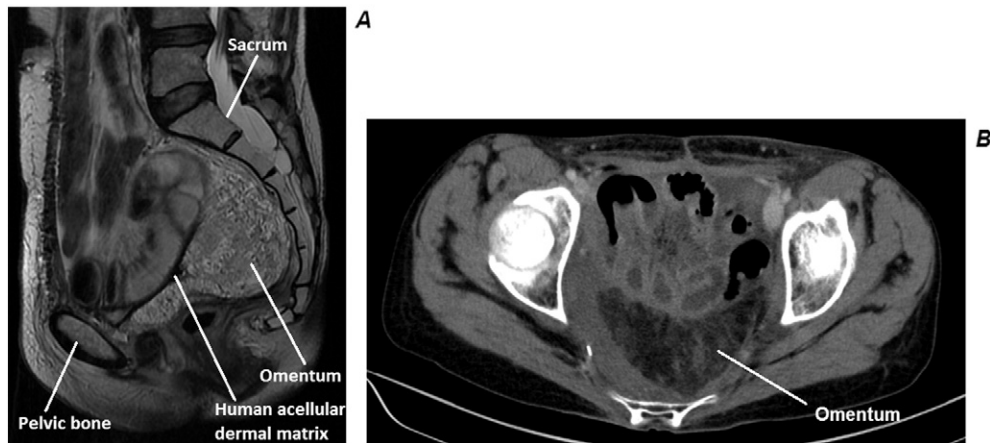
Final imaging result, 2A Final result at MRI performed 30 days after surgery. 3B Final result at CT-scan performed 6 months after surgery.
